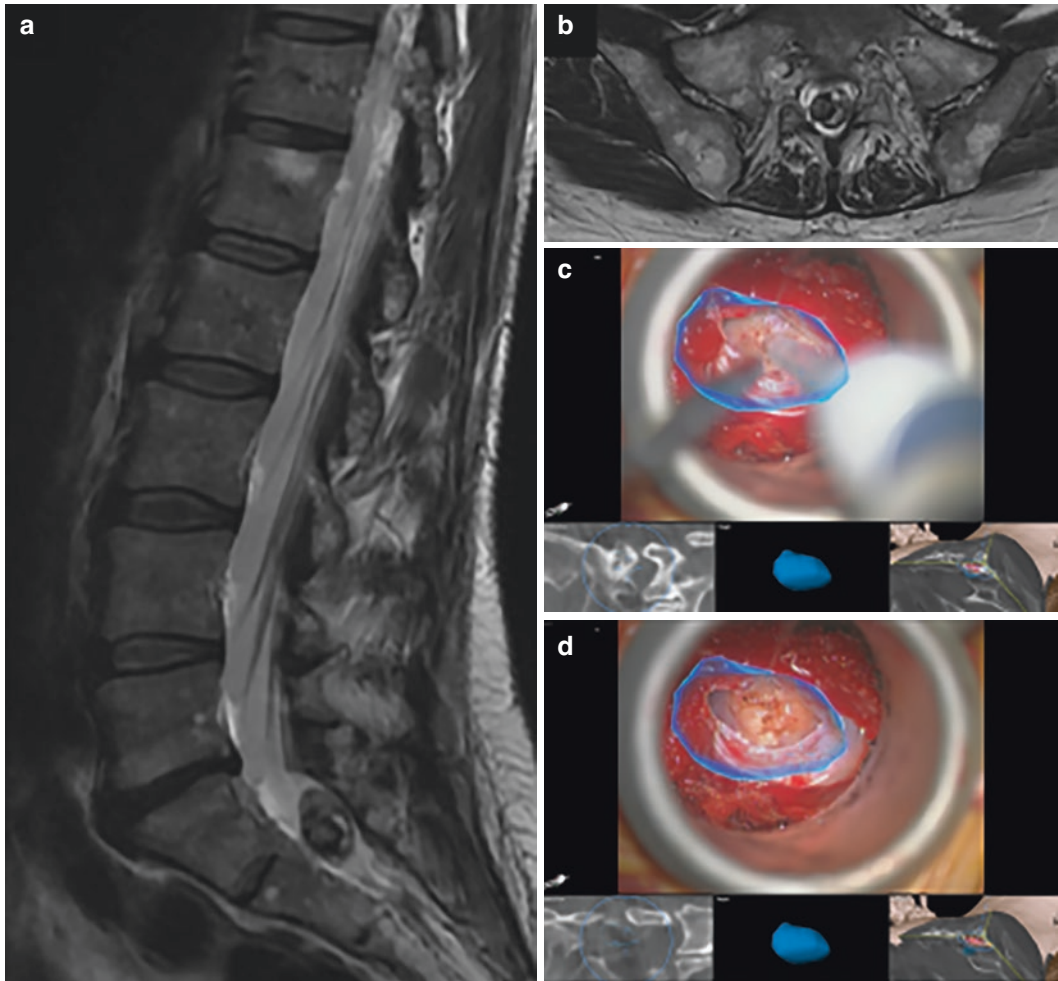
(a) Sagittal and (b) Axial T2-weighted MRI demonstrating sacral schwannoma. After these preoperatively acquired scans were co-registered with intraoperatively acquired CT, an augmented reality projection was superimposed. (c) Tubular approach to mass with blue
